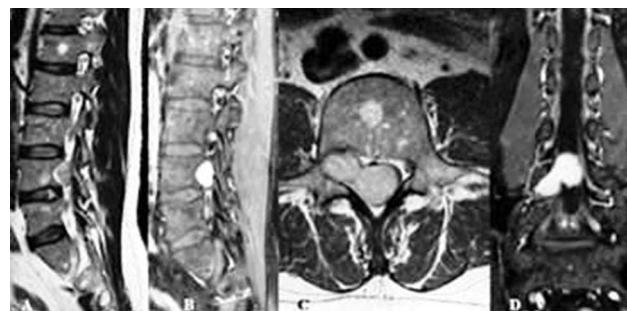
MRI of a schwannoma at the level of L4 vertebra. A) T1 MRI sagittal view without enhancement demonstrating enlargement of the neuroforamen and remodeling of dorsal wall of L4 vertebra; B) – D) Enhanced T1 MRI in sagittal, axial and coronal views show the homogeneous accumulation of contrast and tumour propagation along the L5 nerve root.
